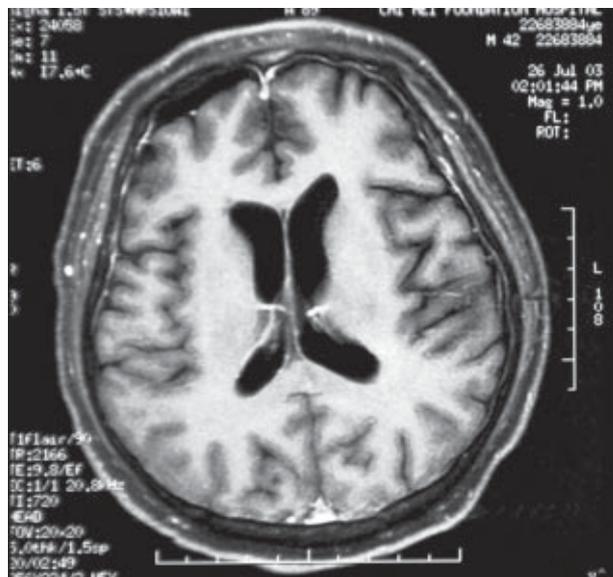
Post-shunting enhanced magnetic resonance imaging reveals a dramatic improvement of internal hydrocephalus with diffuse leptomeningeal enhancement and small subdural effusion over the right frontal area.
